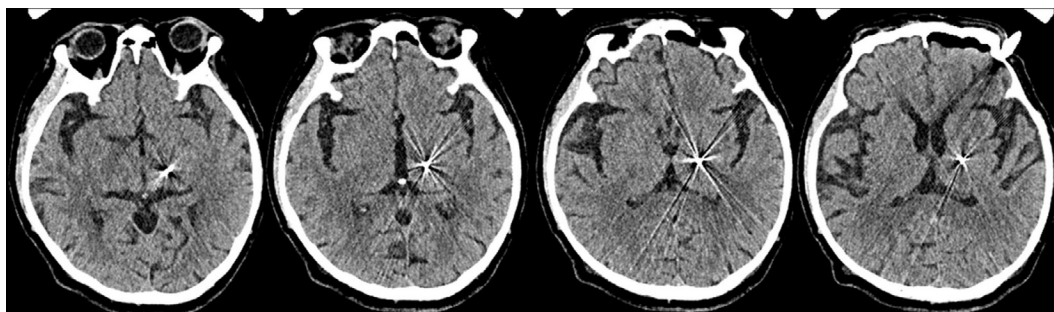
Position of the deep brain stimulation electrode as visualized by postoperative computed tomography.
